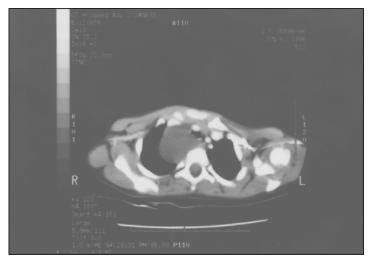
CT scan showed a right mediastinal cyst closely related to the esophagus and trachea. (Oral contrast study showed no communication between the esophagus and the cyst).
